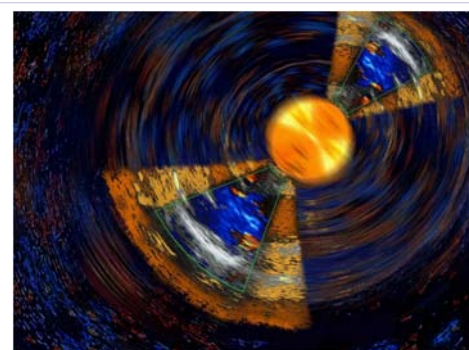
The heart micro-pulsar created by two echocardiographic images which were modified in the Photoshop.
